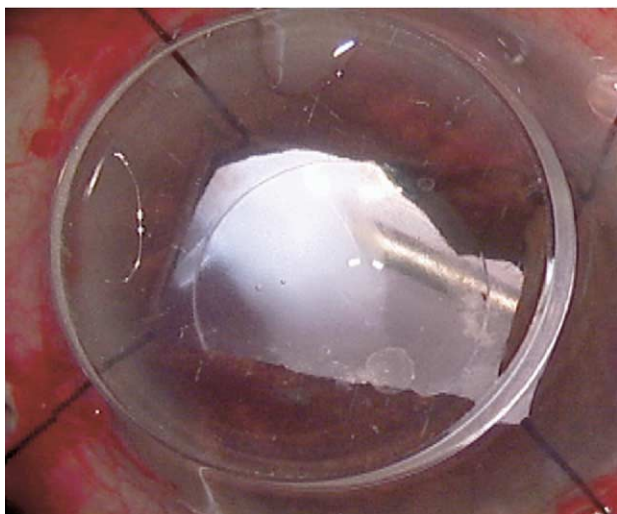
Intruded buckle at the beginning of surgery. Pars plana ultrasonic fragmentation was used to remove intruded Miragel's buckle from the vitreous cavity.
